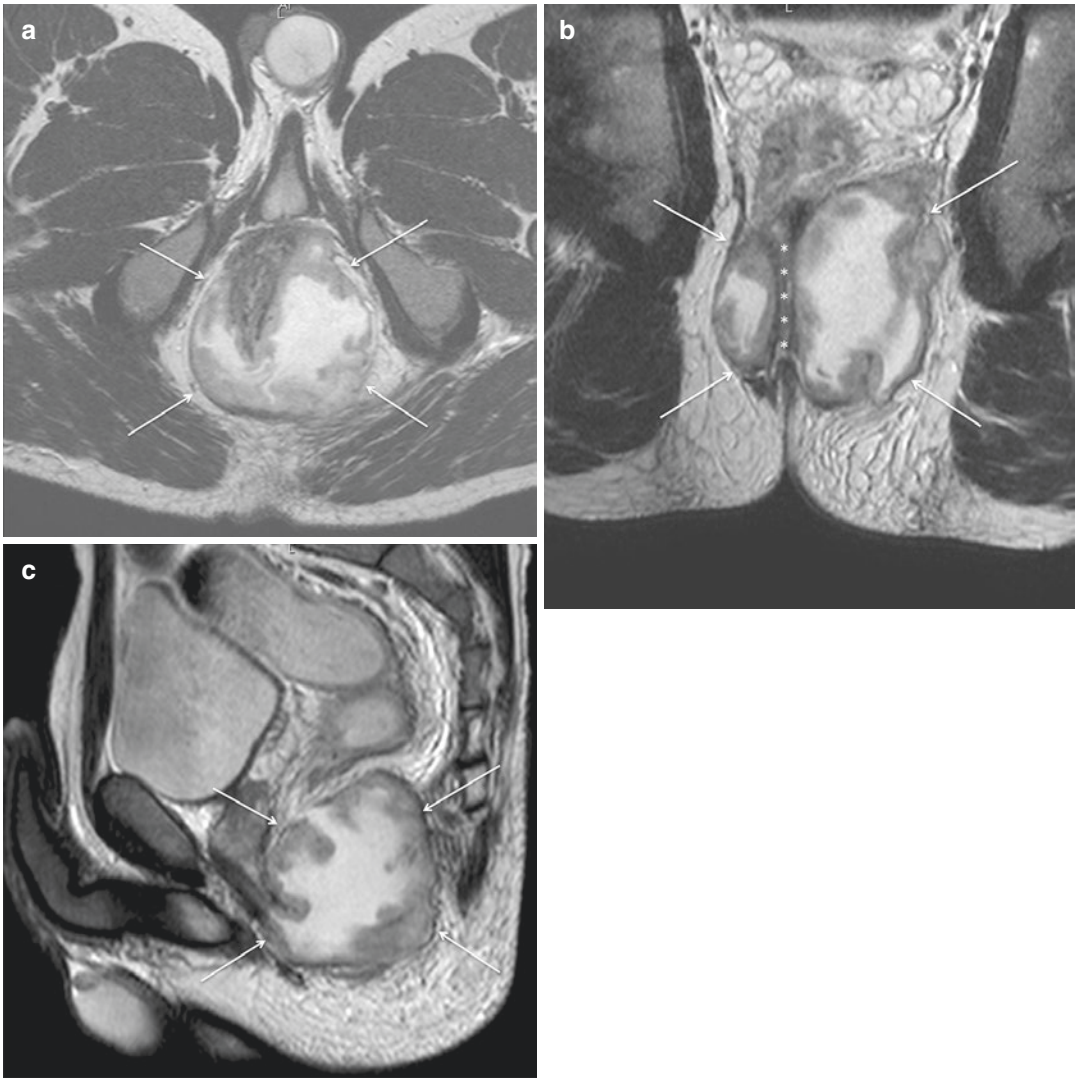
Perianal abscess. Axial-oblique (a), coronal-oblique (b), and sagittal (c) T2-weighted TSE images show a voluminous perianal abscess (arrows) that displaces to the right side of the sphincteric complex (asterisks)
